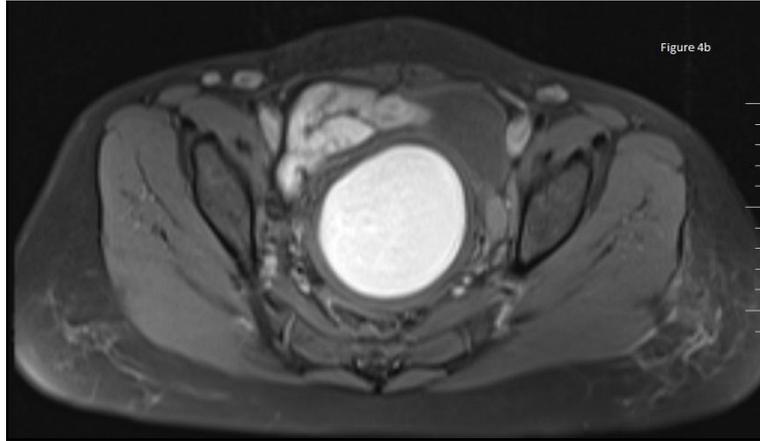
MRI – showing hematometra appearing hyperintense on axial T1 FATSAT.
